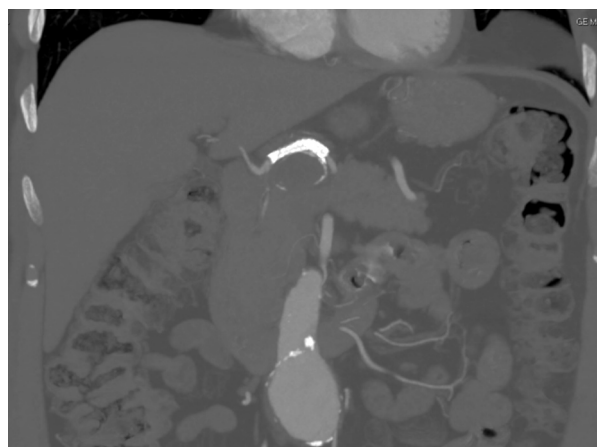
Follow-up CTA after endovascular treatment of the hepatic artery aneurysm, without evidence of endoleaks
